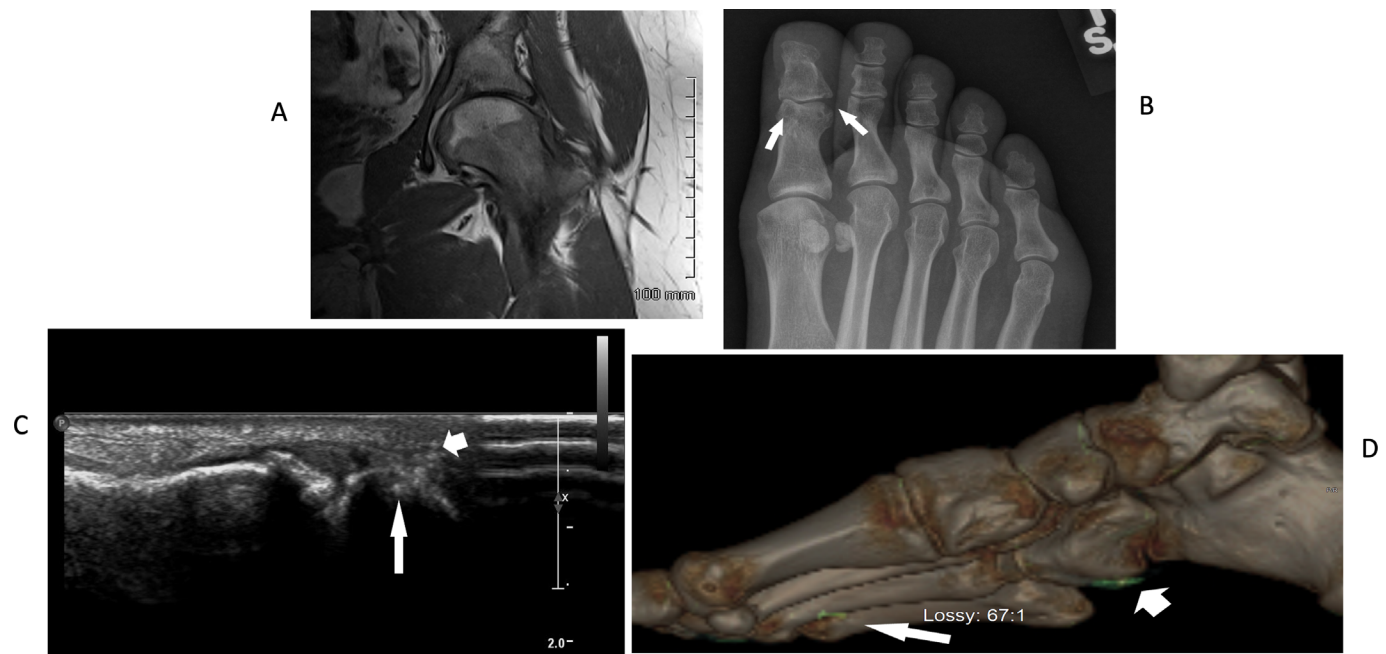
Skeletal imaging in the female proband confirms urate crystal deposition in multiple joints and erosive disease. A, Left hip magnetic resonance imaging revealed inflammatory synovitis, joint effusion, and articular cartilage loss. B, Foot radiographs revealed classic punched-out great toe joint interphalangeal joint erosions, with well-defined margins (arrows), features characteristic of tophaceous, erosive gout. C, Ultrasound of first metatarsophalangeal joint revealed hyperechoic areas consistent with urate crystal deposits (arrowhead), accompanied by cortical erosion (arrow). D, Dual-energy computed tomography of the foot confirmed urate crystalline macroaggregates affecting foot joints and surrounding soft tissues (arrows). Color figure can be viewed in the online issue, which is available at <http://onlinelibrary.wiley.com/doi/10.1002/art.42413/abstract>.
